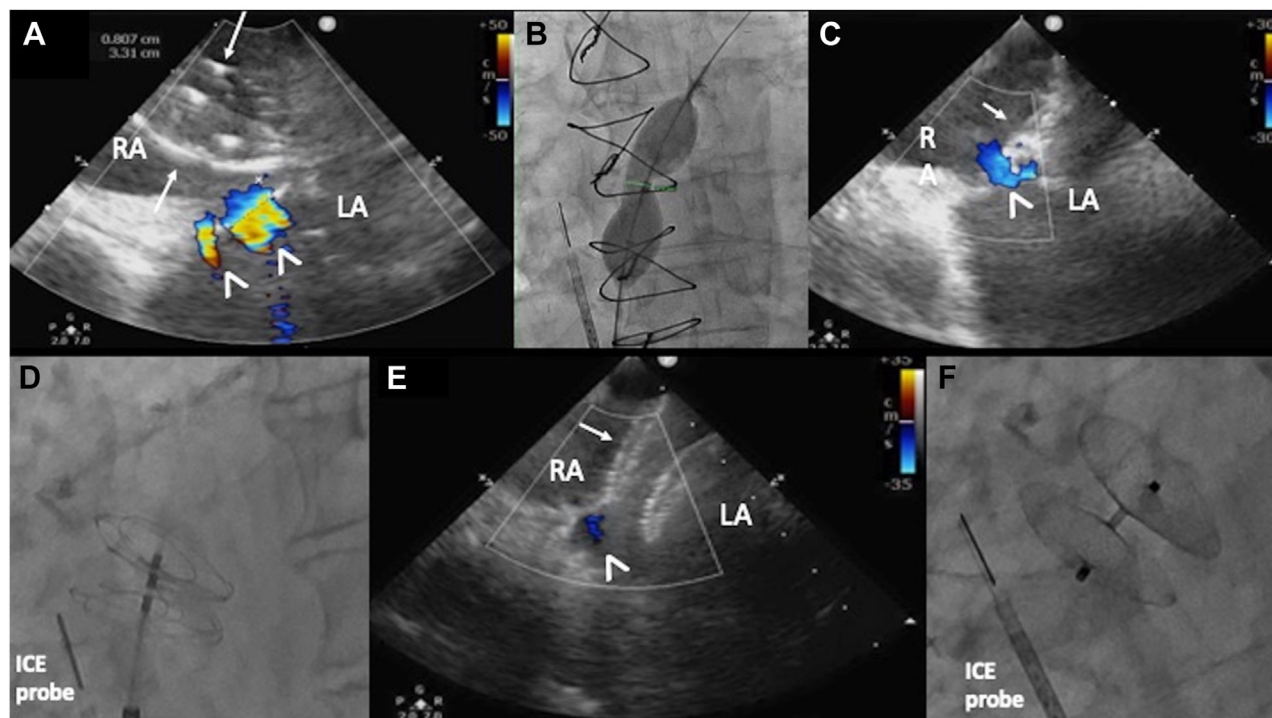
Intra-cardiac echocardiographic (ICE) and fluoroscopic images during the procedure. (A) ICE showing balloon occlusion of the patent foramen ovale (PFO) (between arrows), arrowheads showing 2 atrial septal defects (8 mm and 3 mm in diameter). (B) Fluoroscopic images showing balloon occlusion of the PFO (8 mm in diameter). (C) ICE images showing the 30-mm GORE CARDIOFORM Septal Occluder (Gore Medical, Flagstaff, AZ) (arrow) and a residual shunt through the atrial septal defects (arrowheads). (D) Fluoroscopic image showing the 30-mm GORE CARDIOFORM Septal Occluder. (E) ICE images showing the 35-mm Cribriform Amplatzer Septal Occluder (Abbott Vascular, Abbott Park, IL) (arrow) and a minor residual shunt through the small atrial septal defect (arrowhead). The larger septal defect is covered by the device. (F) Fluoroscopic image showing the 35-mm Cribriform Amplatzer Septal Occluder. LA, left atrium; RA, right atrium.
